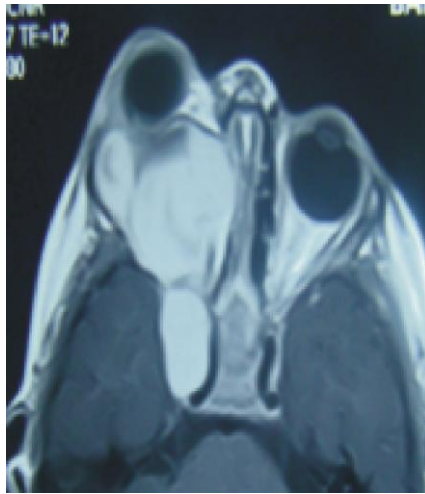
Contrast Axial MRI.*
